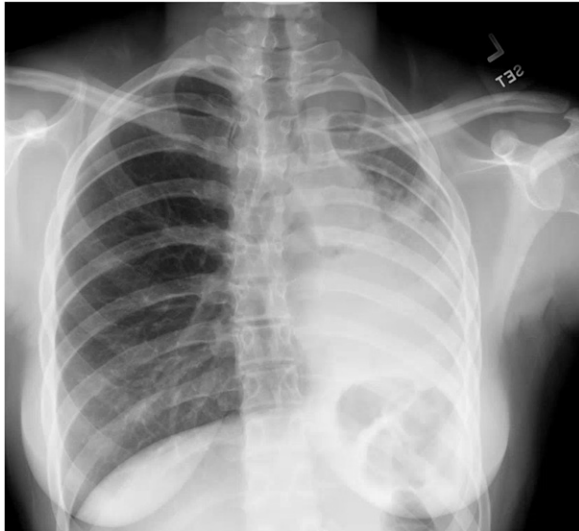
Chest radiograph on hospital admission.
